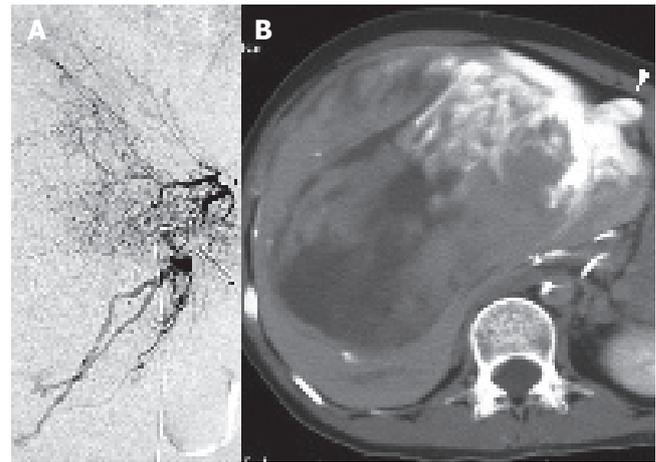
Preoperative angiography. A: Hepatic arteriography; B: CT during cystic arteriography. Many arteries (i.e., right, middle, left hepatic, and subphrenic arteries) fed the tumor (A) (arrow head: the root of cystic artery). However, CT during the selective cystic arteriographies revealed stronger enhancement of the tumor than during any other arteriographies (B) (arrow head: gallbladder).
